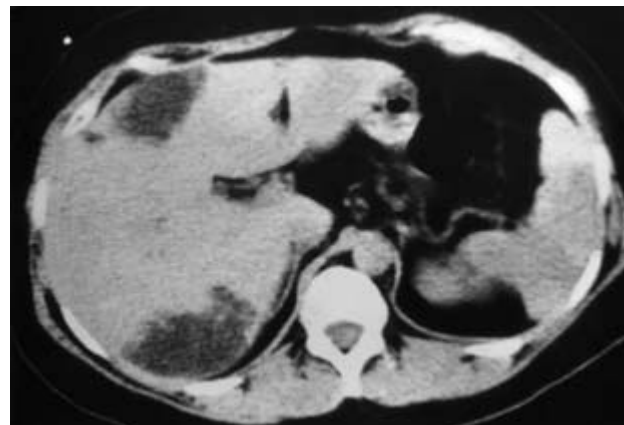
The same patient as in fig. 25.6. A further CT scan performed 6 months later showed two further areas of focal filling defects anteriorly and posteriorly in the right lobe of the liver.
